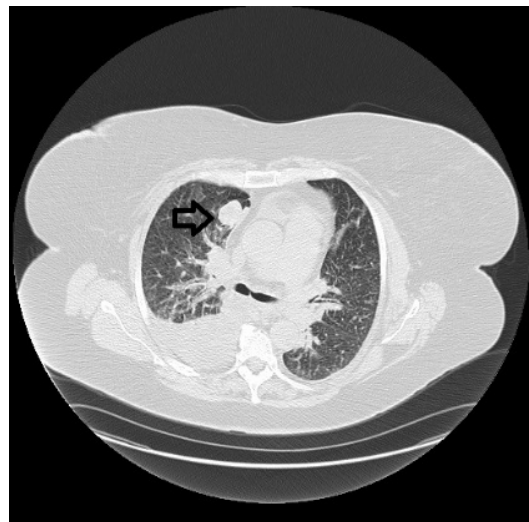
Lung nodule and right pleural effusion on CT chest prior to admission.
